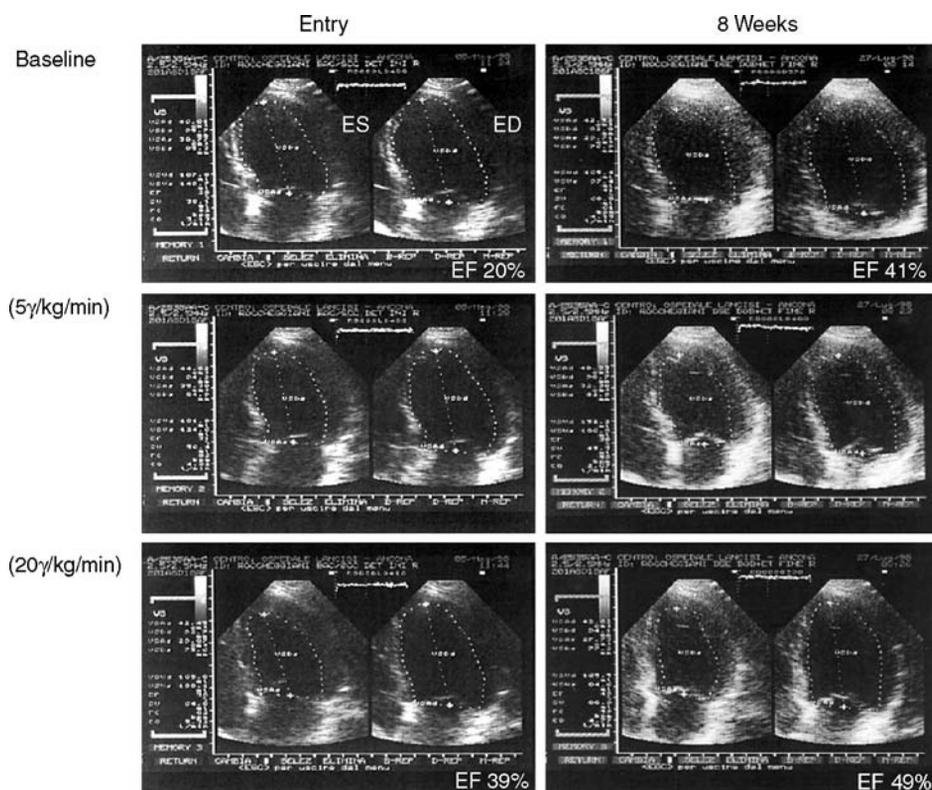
Effects of trimetazidine on left ventricular contractility in a 56-year-old man with ischemic cardiomyopathy. The contractile response was evaluated with stress echocardiography (low-dose dobutamine: increasing by 5  $\mu\text{g}/\text{kg}$  per min every 3 min, up 20  $\mu\text{g}/\text{kg}$  per min) before and after 8 weeks of treatment. There was an improvement in the contractile response of septal segments, resulting in a greater ejection fraction at peak dobutamine infusion. ED, end-diastole; EF, ejection fraction; ES, end-systole.
